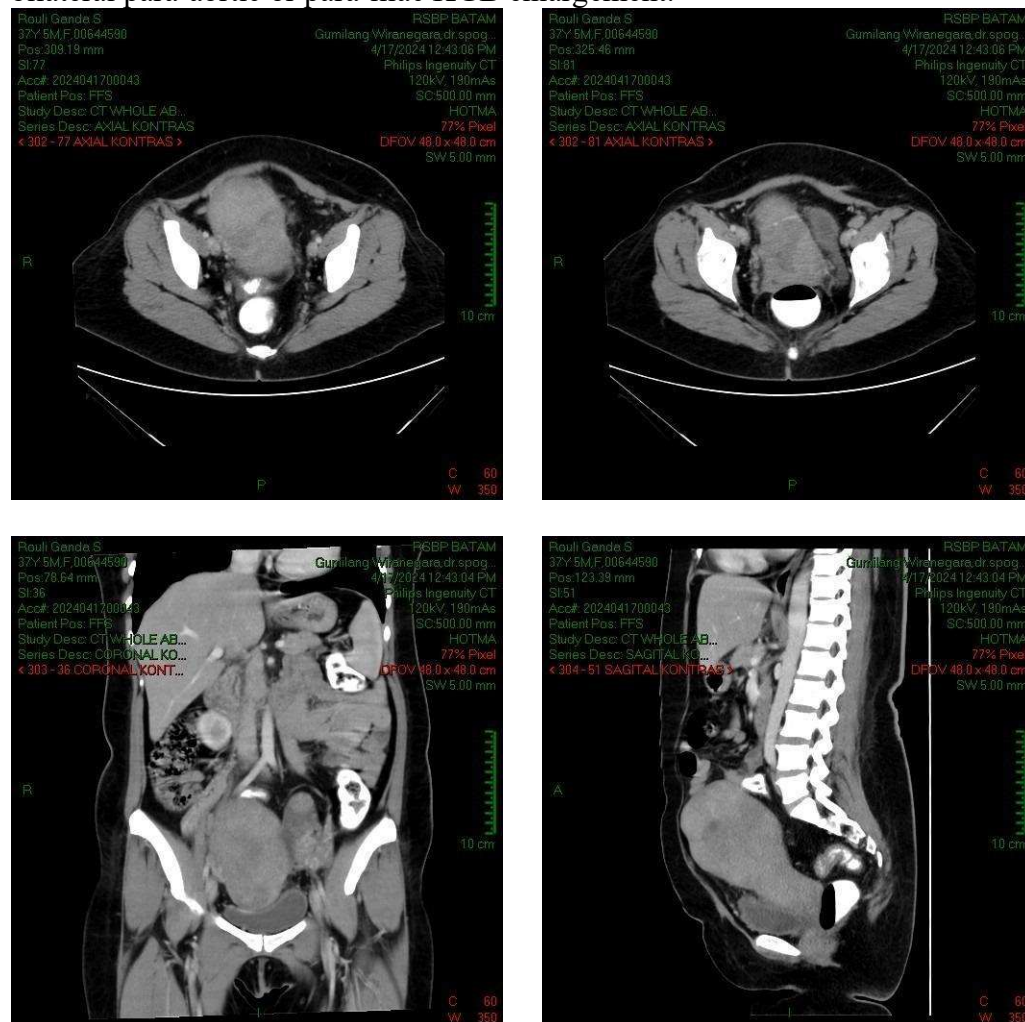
CT Scan Image with Contrast
